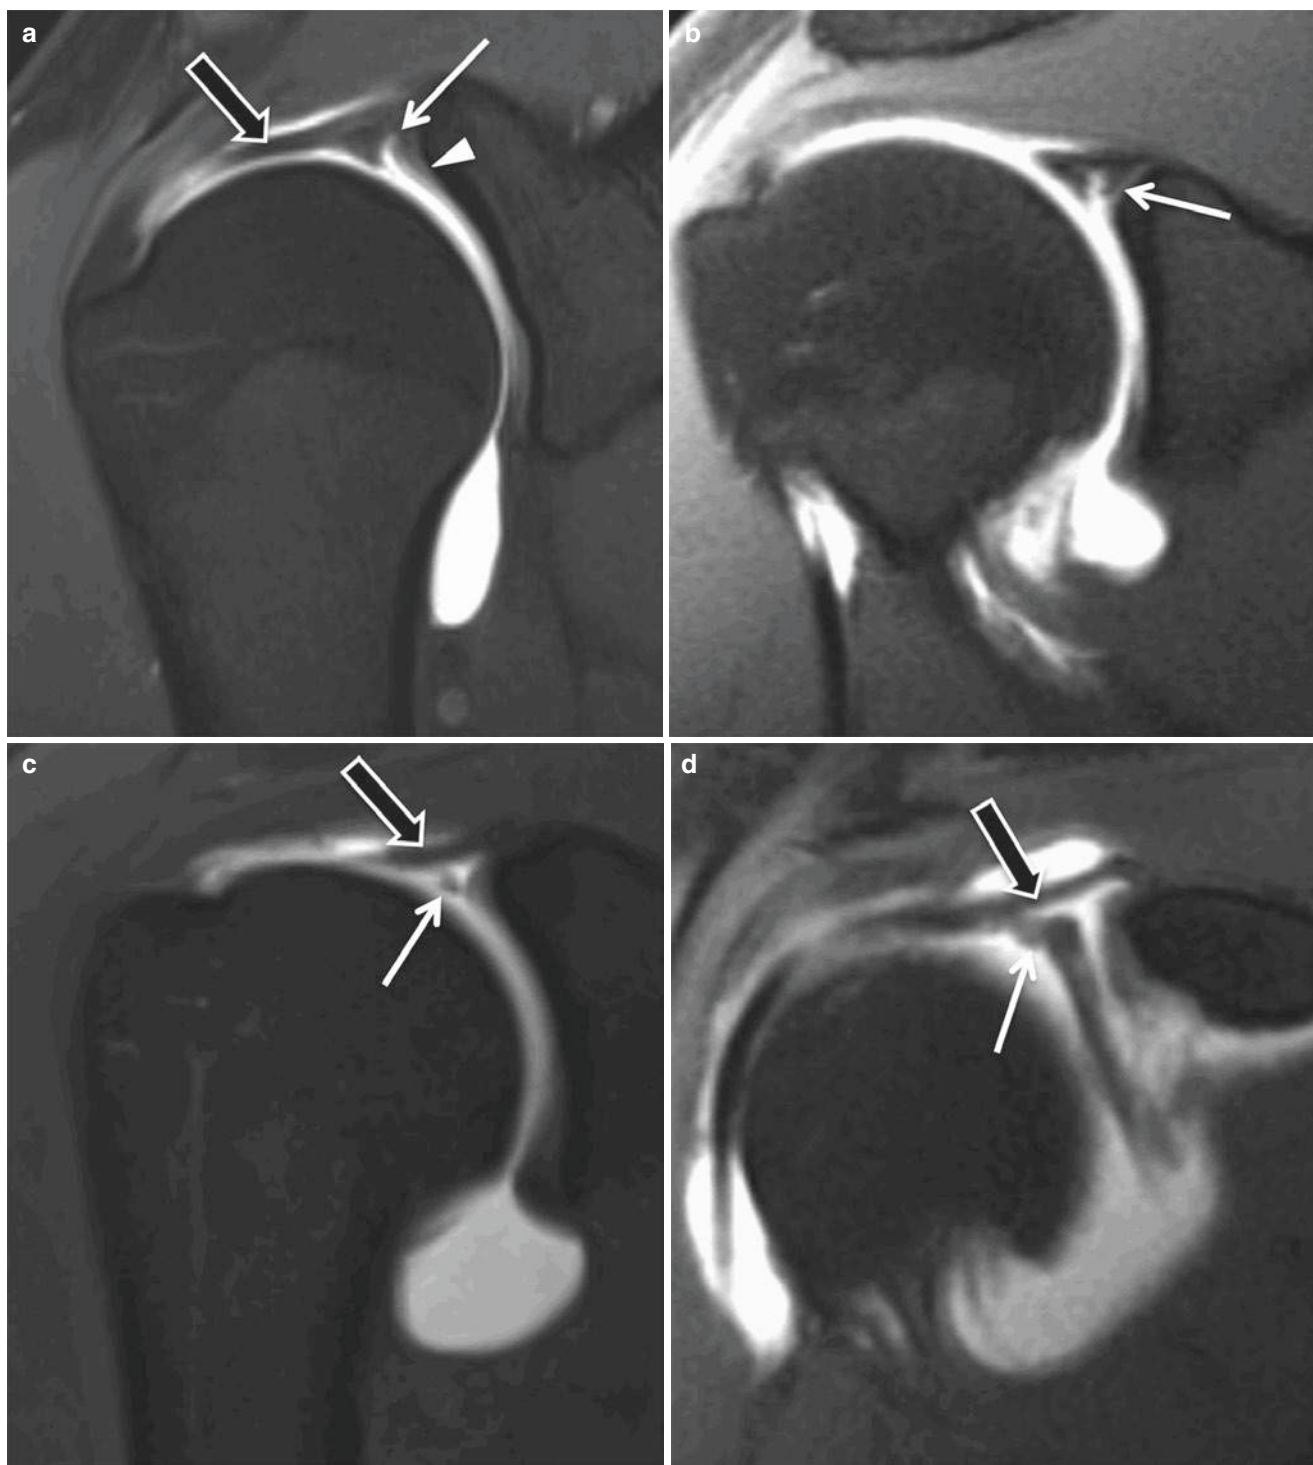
Coronal fat suppressed T1-weighted MR arthrographic images showing a sublabral recess (a), SLAP type II lesion (b), SLAP type III lesion (c) and SLAP type lesion IV (d). a. Note the smooth margins and the parallel orientation to the underlying glenoid cartilage (*arrowhead*) of the sublabral sulcus (*thin arrow*). b. The SLAP type II lesion involves the superior labrum/biceps anchor, has irregular margins and a more
